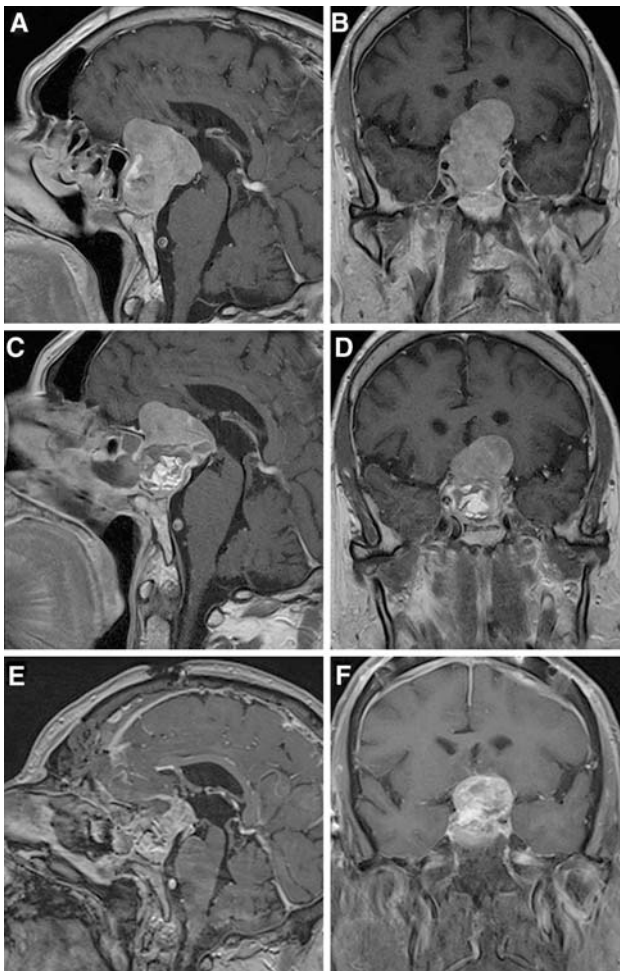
Sagittal and coronal MR images. a, b A large sellar and suprasellar lesion, initially interpreted as recurrence of the previously resected adenoma. c, d Partial removal after trans-sphenoidal approach. e, f Excision of suprasellar remnant following craniotomy
